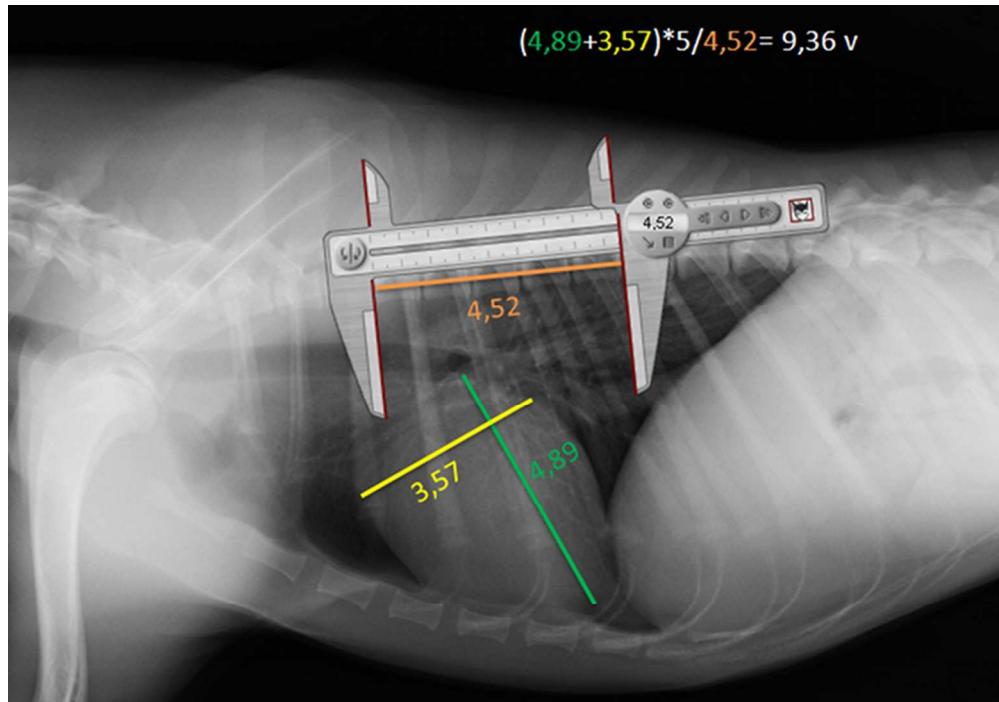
Right laterolateral thoracic radiograph. Objective Vertebral Heart Scale (Objective VHS), long (green line), short (yellow line) cardiac axes and T4-T8 distance (orange line) are shown (4,89 cm, 3,57 cm and 4,52 cm respectively). Screen caliper is shown measuring T4-T8 distance in cm. VHS is expressed as total units of vertebral length after direct standardization: 9.36v.
